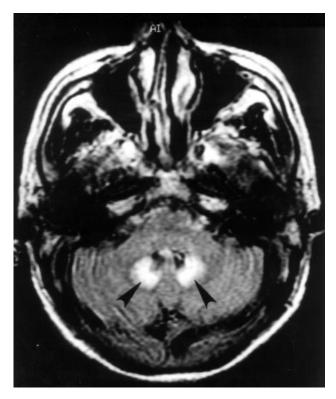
Magnetic resonance imaging after eight weeks of metronidazole therapy, with toxic metronidazole serum concentrations and metronidazoleinduced central nervous system dysfunction and peripheral neuropathy. The arrows mark the increased signal intensity below, behind, and lateral to the fourth ventricle.
